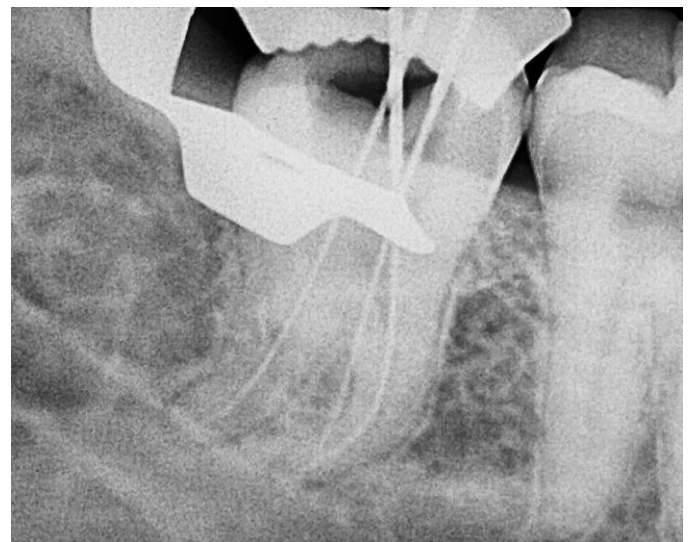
B: Working length Radiograph
